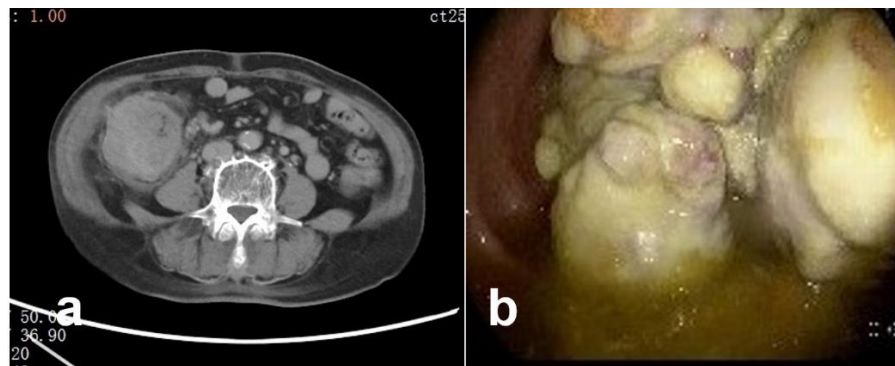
(a) Thickened ascending colonic wall by CT image. (b) Cauliflower-like tumor in the ascending colon lumen by colonoscopy
